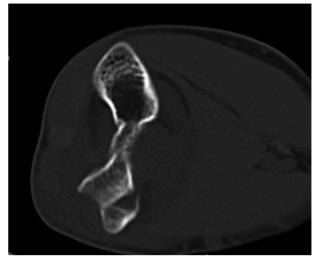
A significant anterior displacement was seen on axial CT section of the same elbow
